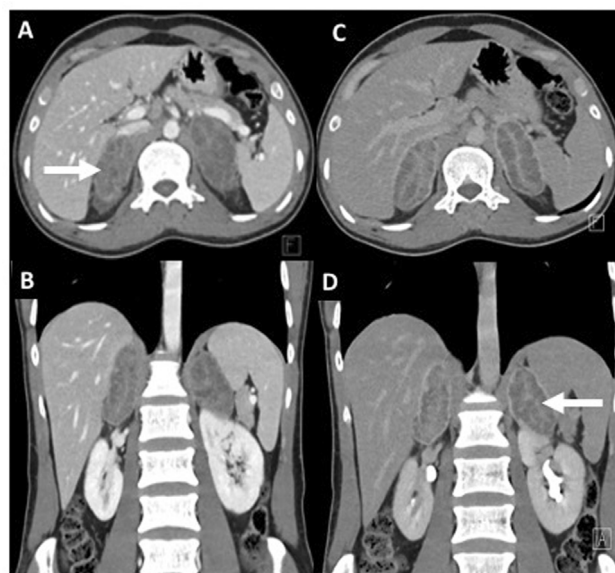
Computed tomography venous (A, B) and delayed (C, D) phases showing bilateral ovoid enlargement of the adrenal glands (white arrows) with peripheral enhancement and nodular central hypoenhancement. No definite adrenal hemorrhage, calcification, or necrosis.
